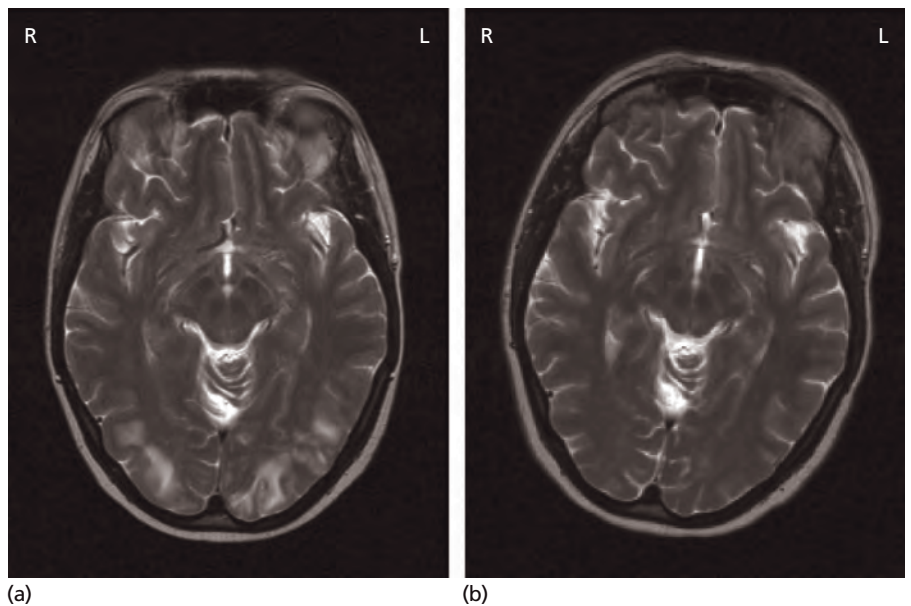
Posterior reversible leucoencephalopathy in a patient who was hypertensive following the administration of intrathecal methotrexate. MRI T2W: (a) following intrathecal methotrexate; and (b) 3 months later showing complete resolution. (Scans courtesy of Dr Paul Holmes, St. Thomas' Hospital.)
